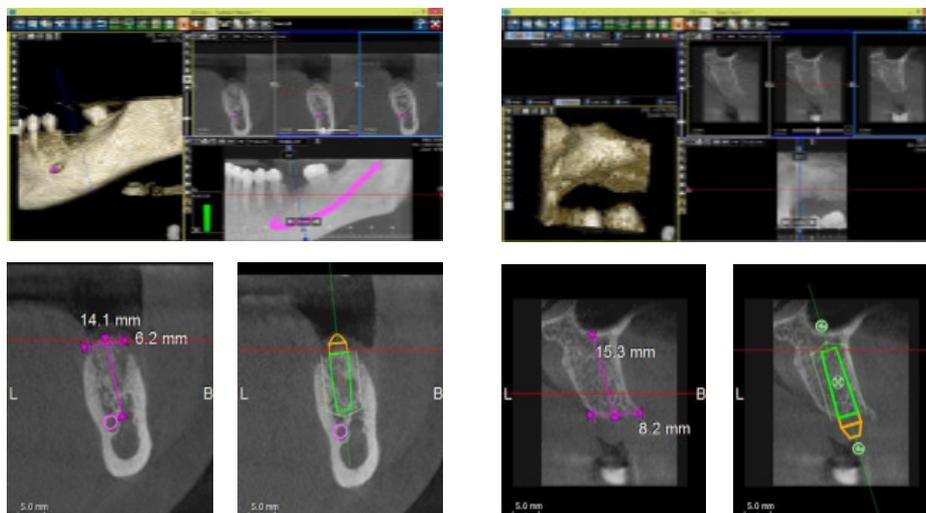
CBCT scan for replacement of missing 36 and 25 respectively
